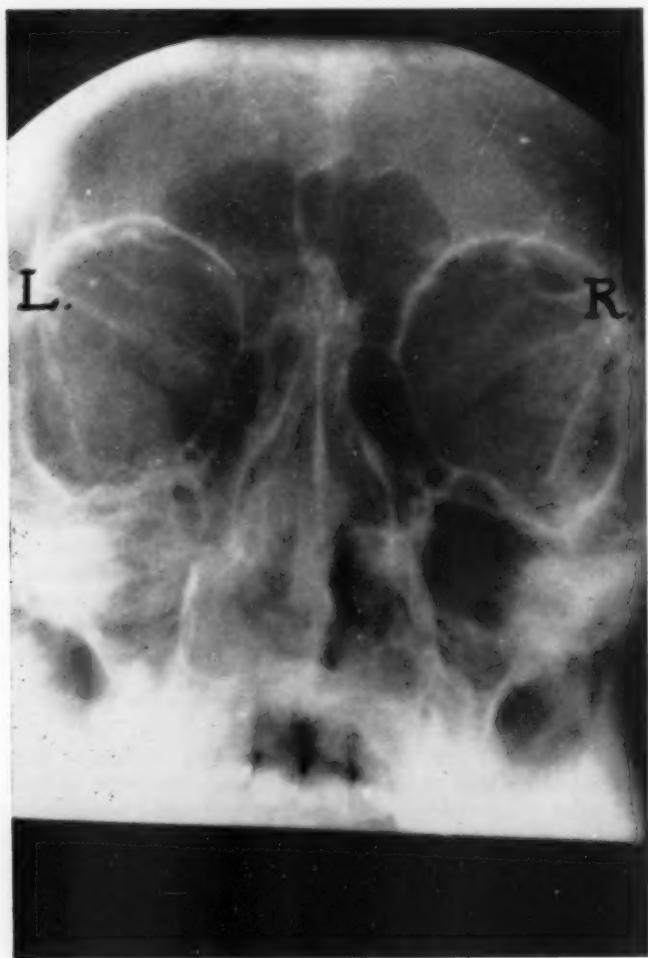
Roentgenogram of nasal sinuses in Nov., 1954, showing only a mild degree of clouding of left maxillary sinus and left ethmoid cells; no bone destruction.
